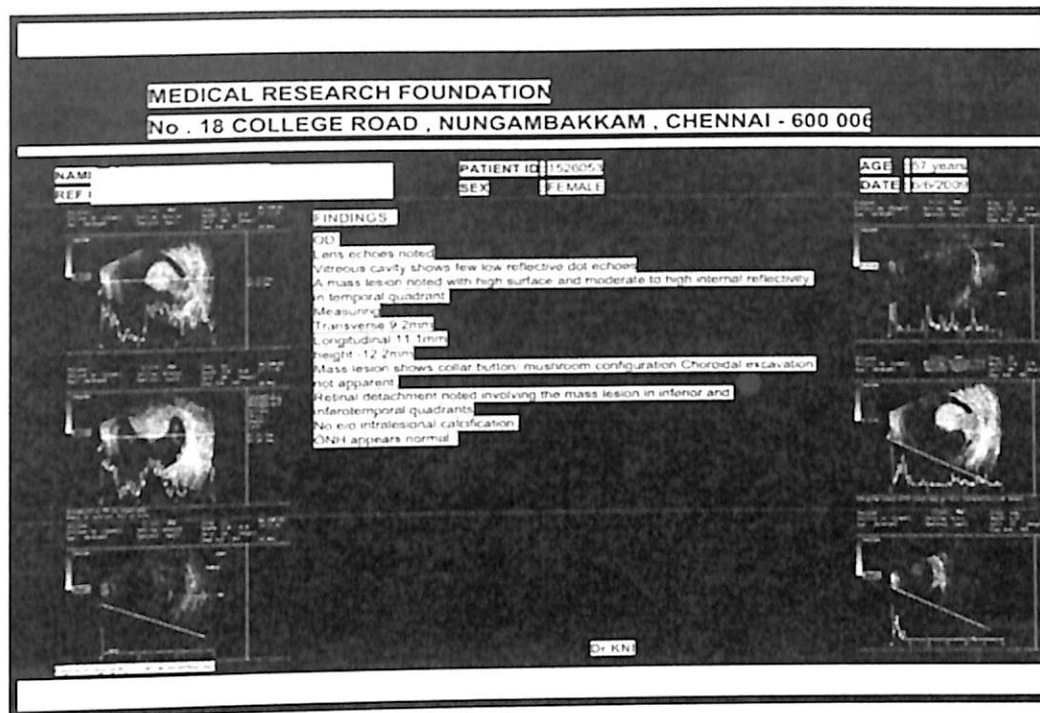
Ultrasound report of UM. The report indicates the presence of a mass lesion of collar button/mushroom shaped, measuring about 9.2 mm x 11.1mm x 12.2 mm with retinal detachment in the right eye (OD) of a patient diagnosed with uveal melanoma.
